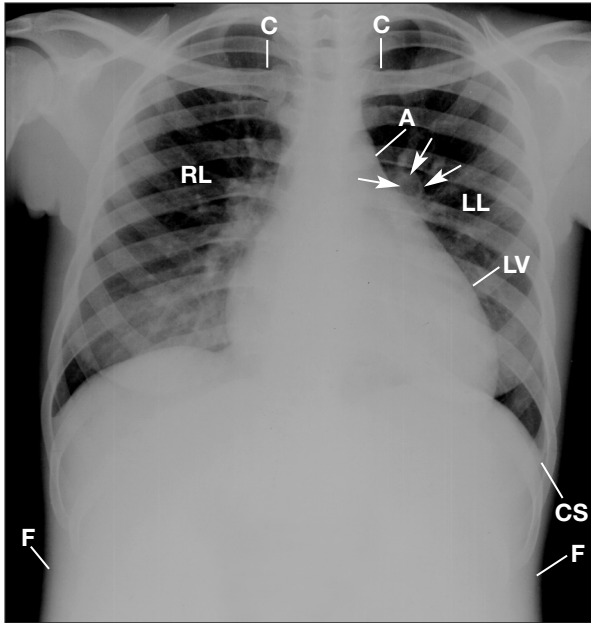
This posteroanterior chest radiograph, compared with Figure 1 (page 17), displays some clearing of diffuse hazy densities; cavitations above the posterior left sixth intercostal space (arrows); prominent pulmonary vascularity; an enlarged left ventricle, suggesting diffuse chamber enlargement or pericardial effusion; blunting of the right and left costophrenic sulci; pleural thickening adjacent to the left costophrenic sulcus, suggesting bilateral pleural effusions, and bulging of the flanks, reflecting ascites.
